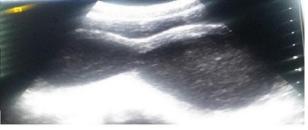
Pelvic ultrasound axial image, showing pelvic mass, bilobe, well limited, with echogenic liquid content, with regular thick wall.
